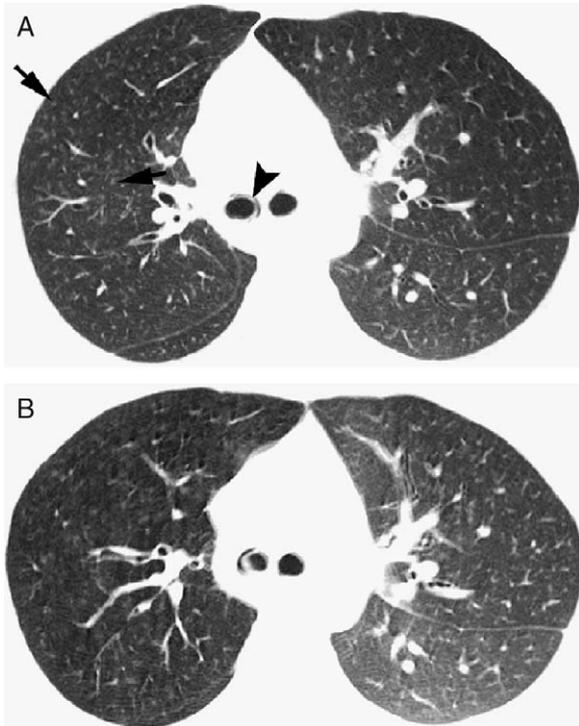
A 23-year-old female cocaine user with partial right bronchial obstruction and air trapping due to inhalation of a straw. A, High-resolution CT image shows a circular opacity in the right mainstem bronchus (arrowhead) and decreased volume of the right lung. Also noted are few small centrilobular nodules in the right upper lobe (arrows). B, Expiratory CT image at the same level as A demonstrates air trapping in the right lung and contralateral mediastinal shift. The foreign body in the right mainstem bronchus was removed bronchoscopically and was proven to be a straw aspirated during rigorous cocaine sniffing. The small centrilobular nodules in the right upper lobe were presumably secondary to postobstructive bronchiolitis.
